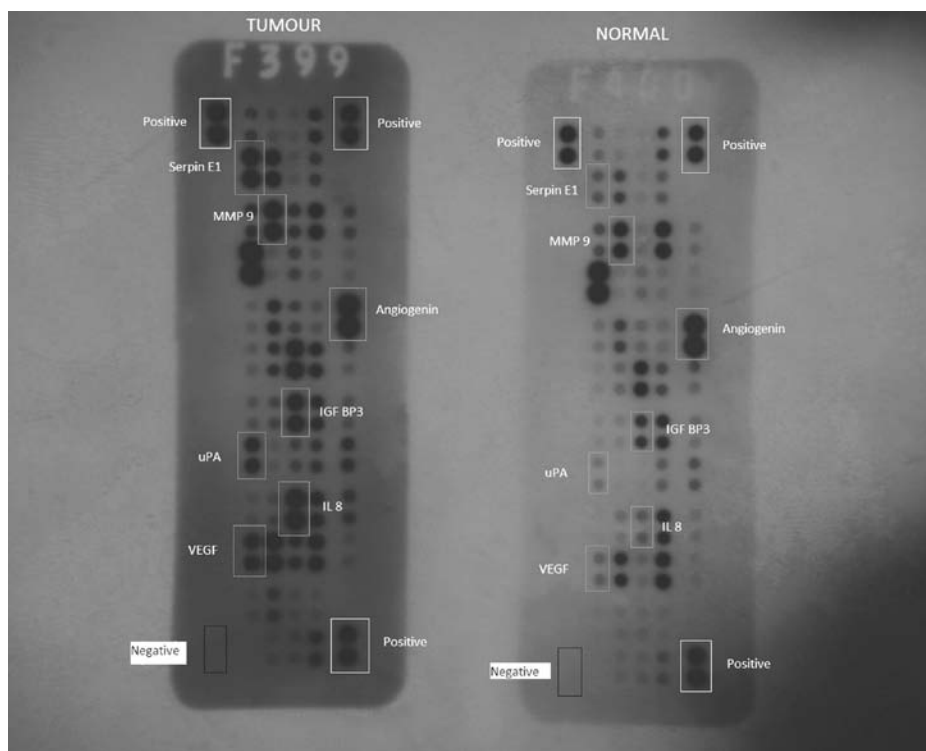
X-ray film of angiogenesis antibody arrays processed to detect proteins in tumour and normal mucosal tissue taken following 10 min of exposure. Grey boxes show examples of differential expression of proteins between tumour and normal mucosal tissue, white boxes are positive control spots and black boxes are negative control spots.
